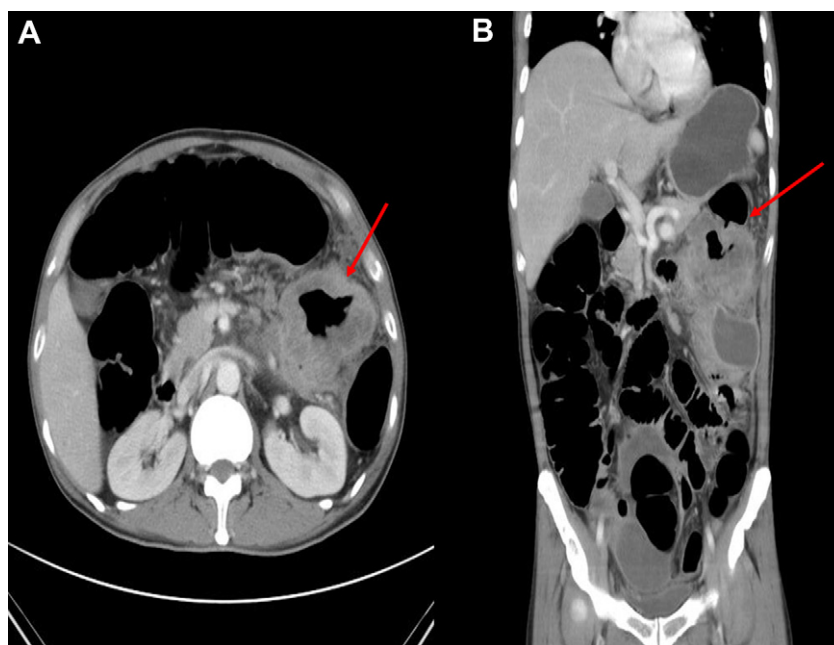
A mass with adjacent tissue invasion at the distal transverse colon was found in a computed tomography (CT) scan of the abdomen. (A) Lesion shown by sagittal view of the abdominal CT scan (arrow). (B) Lesion shown by coronal view of abdominal CT scan (arrow).
